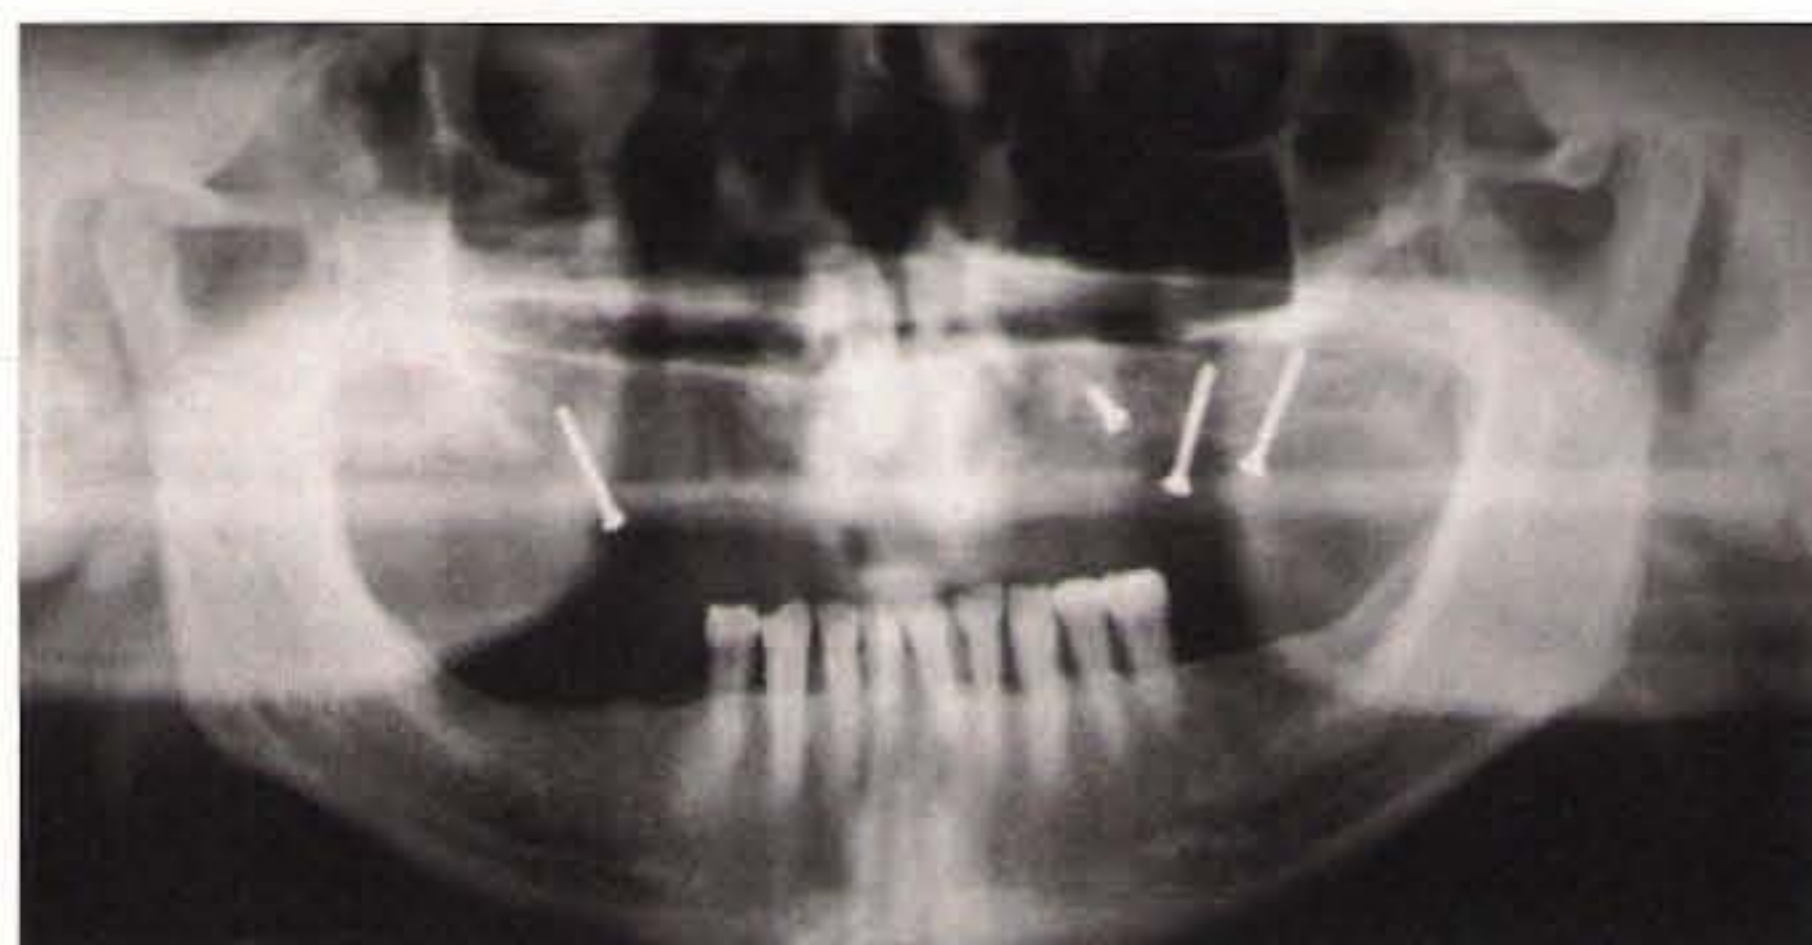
Control panoramic radiograph taken after 6 months.
